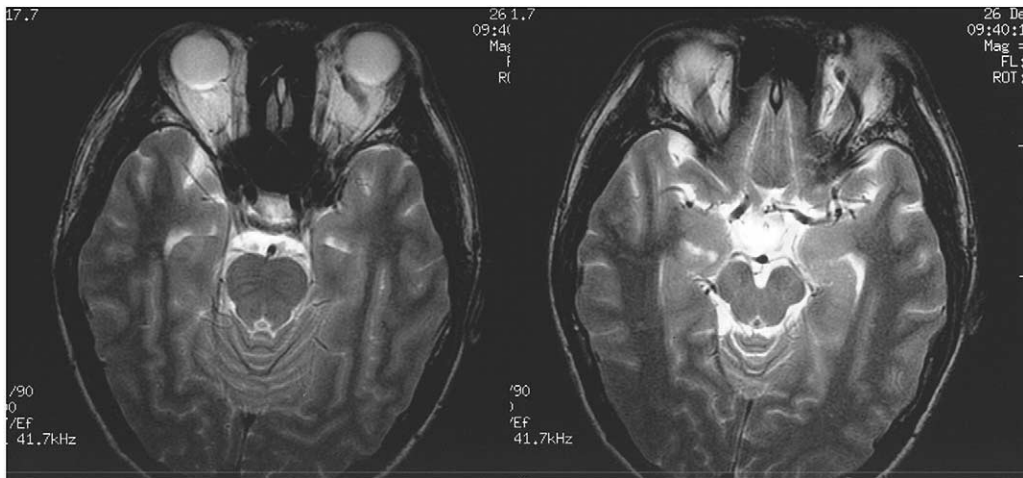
Axial T2-weighted MRI showing the left dilated ophthalmic vein.
